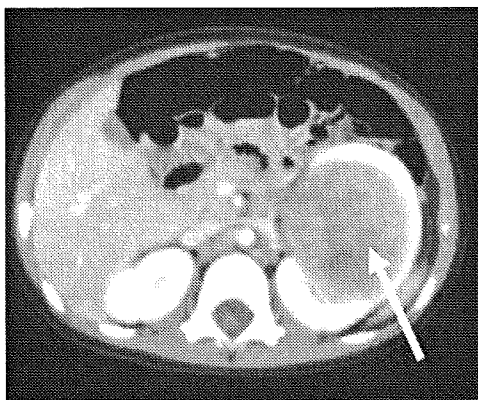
An enhanced computed tomography scan of the abdomen showed tumor (80 mm × 73 mm × 66 mm) at the inferior pole of the left kidney.
